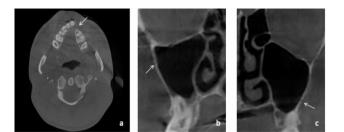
(a) Axial CBCT image showing unilateral CLP on the left side (white arrow), (b) Coronal CBCT image showing PSAC entry in maxillary sinus on NC (white arrow), (c) Coronal CBCT image showing PSAC entry in maxillary sinus on CS (white arrow)
